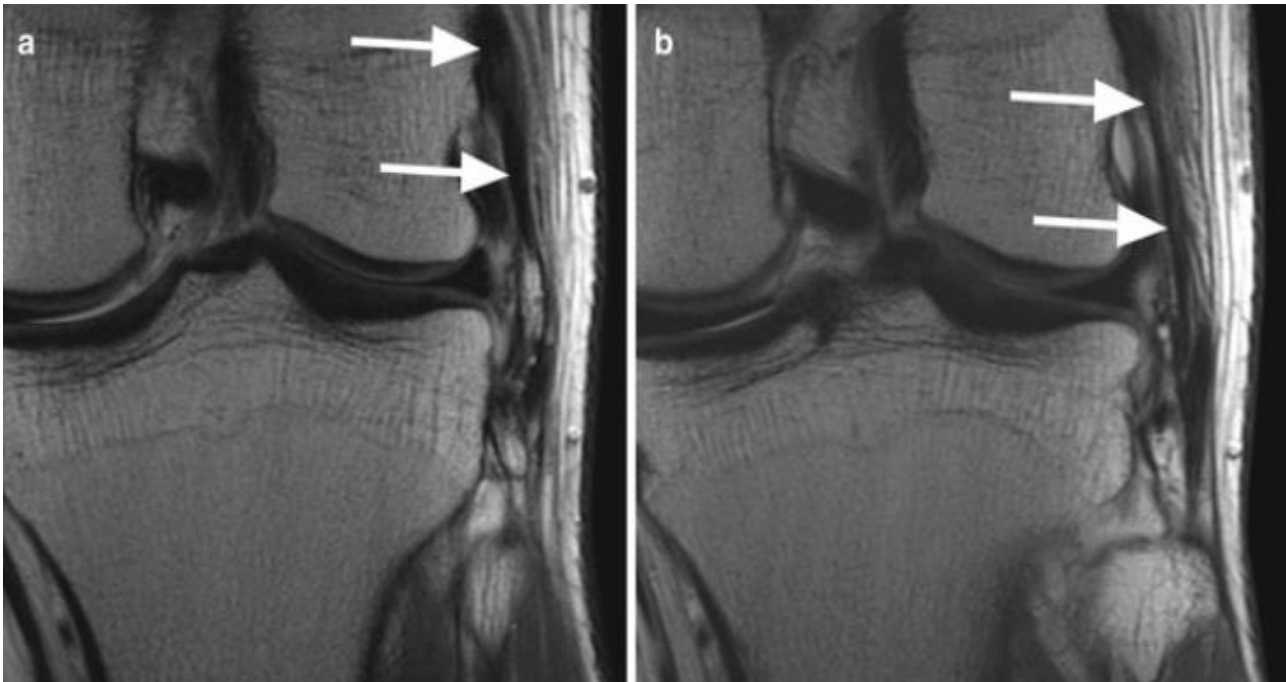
Normal lateral collateral ligament (LCL). Coronal proton-density fat sat MRI images show the normal LCL extending from the lateral femoral condyle to the fibular head (*large arrows in a & b*).
